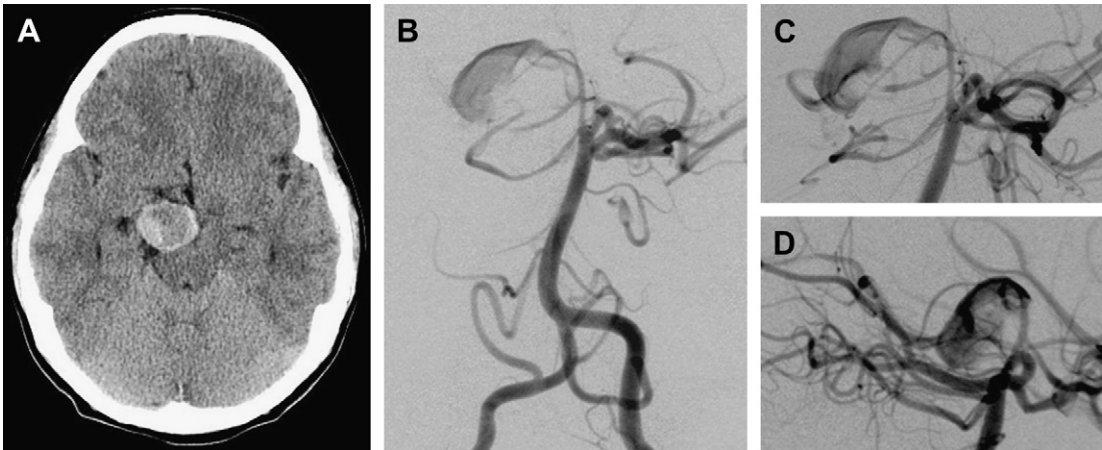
Fusiform aneurysm. A 13-year-old otherwise healthy boy presented with 2 months of headache and right cranial nerve III palsy. A nonenhanced CT scan (A) demonstrates a hyperdense mass in the right suprasellar cistern with mass effect on the midbrain and interpeduncular fossa. Catheter angiography of the left vertebral artery in the AP (B), magnified Water (C), and magnified reverse Schuller (D) projections confirmed the presence of a giant partially thrombosed fusiform in the right P1/P2 posterior cerebral artery aneurysm. This lesion subsequently underwent endovascular coiling, with resolution of the patient’s oculomotor palsy.
